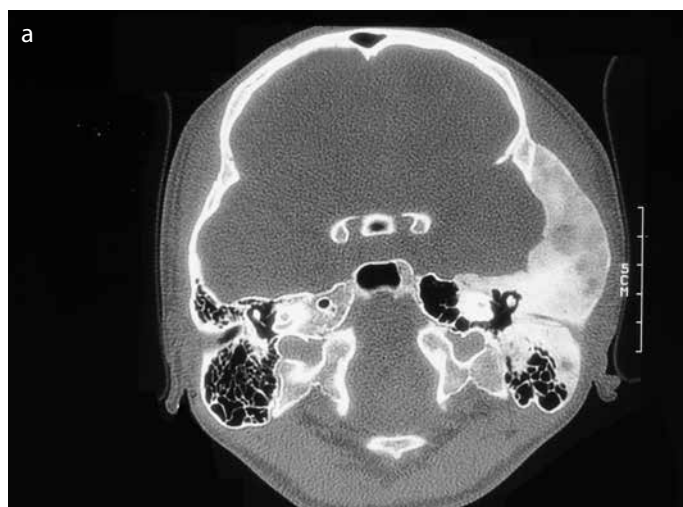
a, b. Axial (a) and coronal (b) views of the non-contrast temporal HRCT showed fibrous dysplasia of the left temporal bone with severe external auditory canal stenosis
